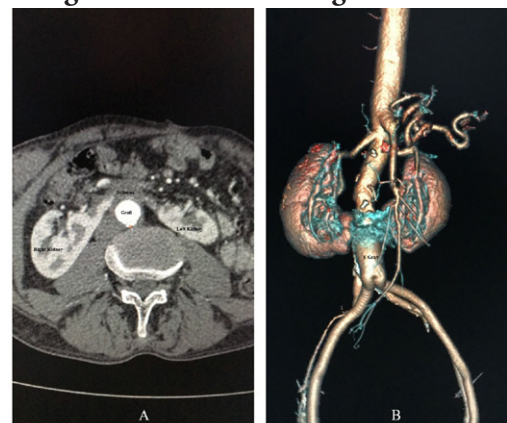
The appearance of horseshoe kidney and dacron graft in postoperative computed tomography; Figure 2B: Horseshoe kidney and dacron graft appearance on multisite computed tomography at postoperative 5th month.
